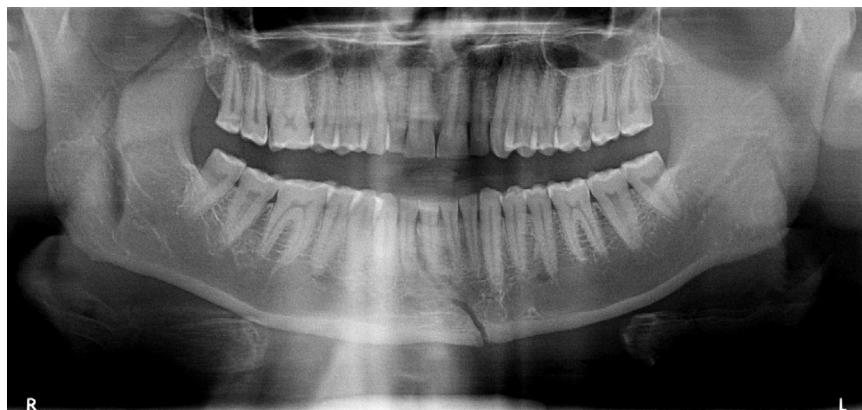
Preoperative panoramic radiograph of a mandibular right parasymphysis fracture.
